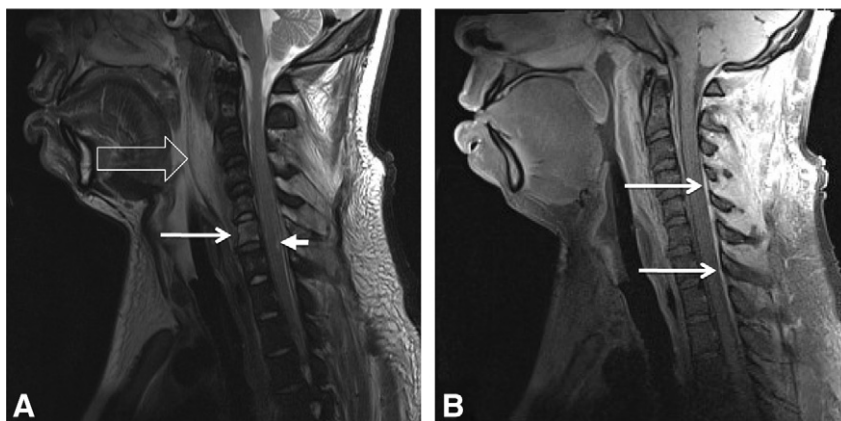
Magnetic resonance imaging of the cervical spine. “A” is T2 sagittal acquisition; “B” is T1 post-gadolinium sagittal acquisition. *White open arrow in “A”* shows phlegmon or abscess within the prevertebral space between C1 and C6. *White long arrow in “A”* shows involvement of C6 vertebral body, likely representing osteomyelitis. *White short arrow in “A”* shows signal abnormality in the spinal cord, representing edema. *White arrows in “B”* show enhancement of the posterior aspect of the cervical epidural space between C4 and T2.
